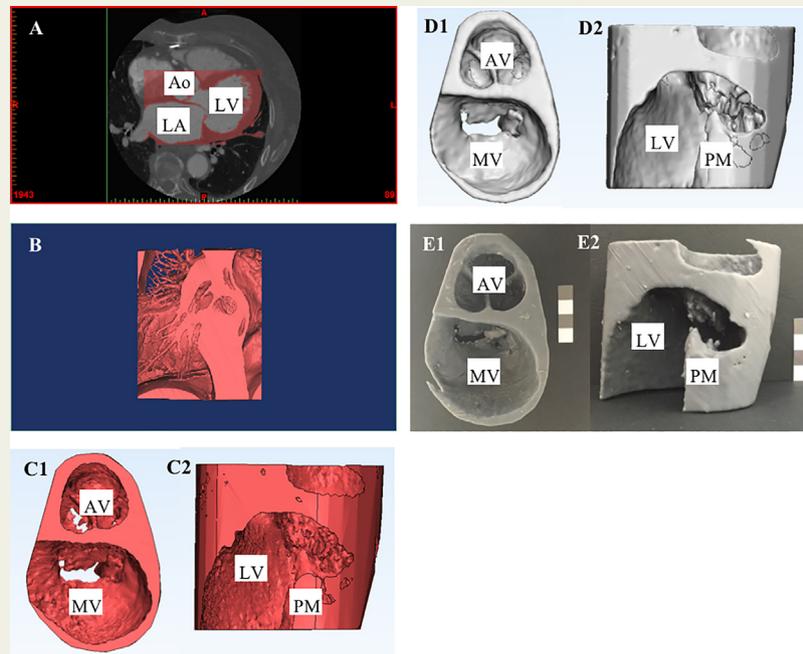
3D MV model produced from cardiac CT imaging data. Cardiac CT scans were segmented (A) and a virtual 3D model was calculated (B). The model was trimmed to isolate the MV apparatus, left ventricular cavity and aortic valve (C) and refined through anatomical engineering (D). The model was then 3D printed using stereolithography (E). Abbreviations: 3D, three dimensional; MV, mitral valve; Ao, aorta; AV, aortic valve; LA, left atrium; LV, left ventricle; MV, mitral valve, PM, papillary muscle. [Note: calibration inset, 10 mm x 10 mm squares].
